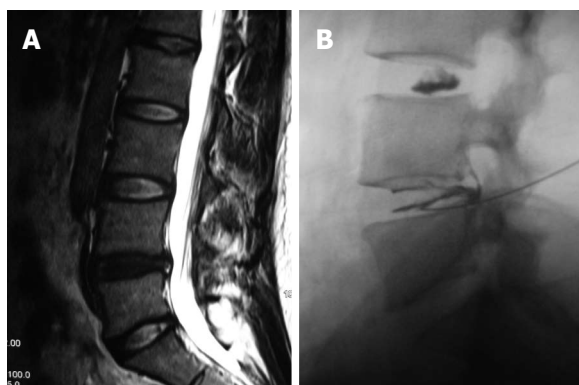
Magnetic resonance imaging and discography. A: A 35-year-old woman had a 5-year history of low back pain. Sagittal T2 weighted magnetic resonance imaging showed L4/5 disc degeneration with a high intensity zone in the posterior annulus fibrosus; B: Discography showed L4/5 disc disruption with exact pain reproduction. After discography, 10 mg methylene blue was injected into the painful disc through discographic needle. Low back pain was almost totally relieved. No recurrence was observed at a 12-mo follow-up interval.
